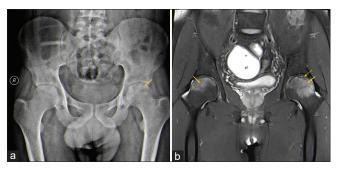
A 47-year-old male with a history of acute pain in the left hip. (a) Radiograph shows articular surface irregularity with thin subcortical sclerotic line (arrow) in the left femoral head. The right femoral head appears normal. (b) Coronal STIR images show hyperintense signal in bilateral femoral heads (arrows), suggesting transient osteoporosis with associated subcortical insufficiency fracture (dashed arrow) in the left femoral head.
